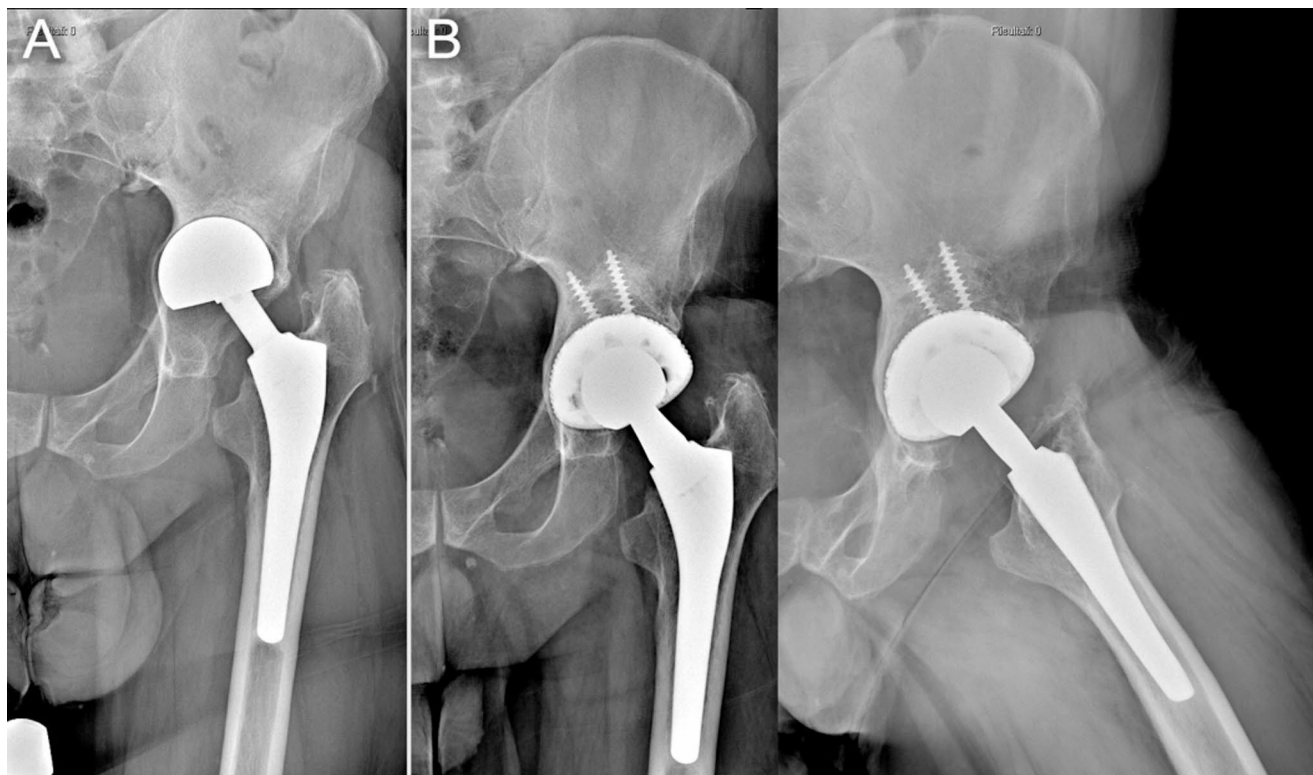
Clinical Case. 48 year-old man, primarily treated with hemiarthroplasty for benign neoplastic lesion of the femoral head. A. Preoperative antero-posterior radiographs: cotyloiditis with proximal migration of the prosthetic head and consumption of the bone stock on the acetabular roof, Paprosky II-C defect [42, 43]. B. 2-years follow-up
